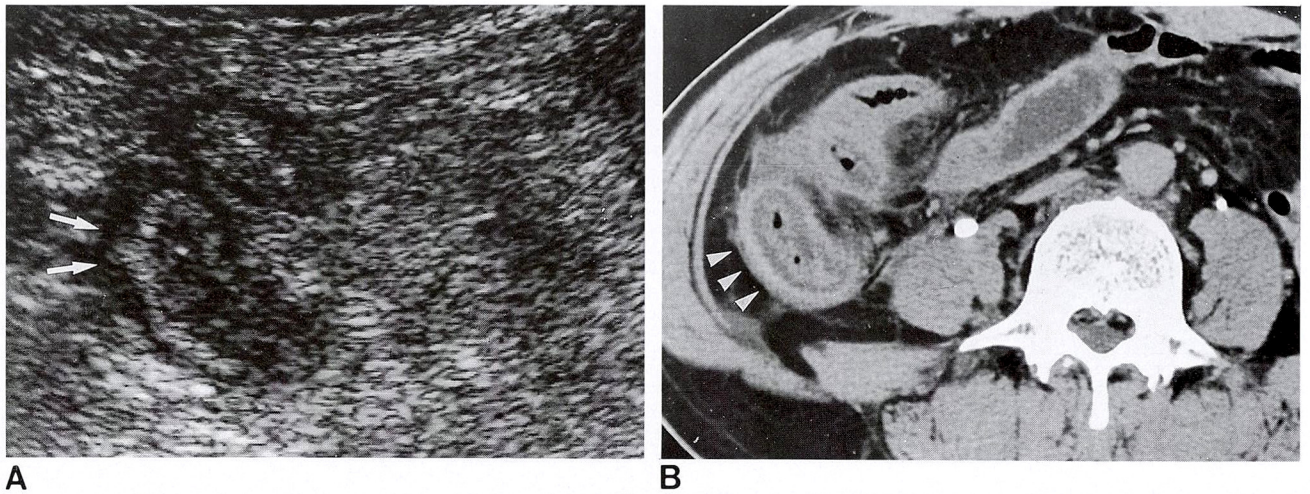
A 56 year old man with right lower abdominal pain. Six months ago, he had a right hemicolectomy due to diverticulitis. A. The ultrasonogram shows target-like inner, middle and outer wall layers (arrows) without bowel wall obliteration. B. The CT scan shows thickened terminal ileum with thickness less than 0.8 cm and well defined bowel wall layers (arrowheads). This case was ileal strangulation with mesenteric adhesion.
